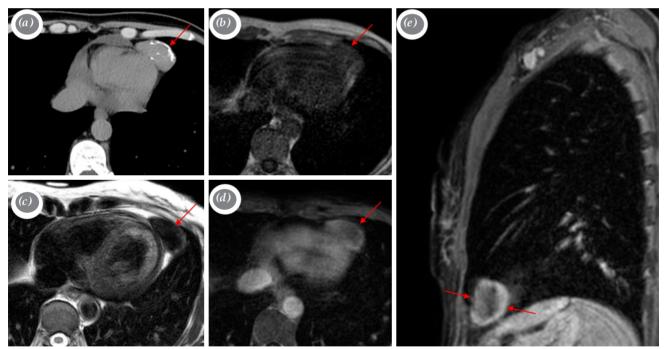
(a) Axial chest CT image shows a well-defined, calcified left cardiophrenic angle mass (arrow). Axial T1-weighted (b) and T2-weighted (c) MRI show hypointense left cardiophrenic angle mass (arrows). Contrast-enhanced axial (d) and sagittal (e) T1-weighted MRI demonstrate mild and heterogeneous enhancement of the mass (arrows).
